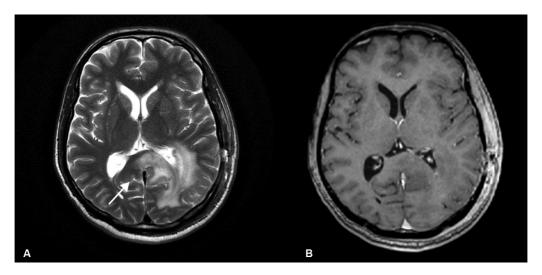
(A and B) Axial T2-weighted and post-contrast T1-weighted images showing diffuse infiltrating lesion in the parieto-occipital lobe, extending up to the splenium of the corpus callosum (white arrow) and the trigone of the left lateral ventricle. (index scan). No suspicious enhancement is present.
